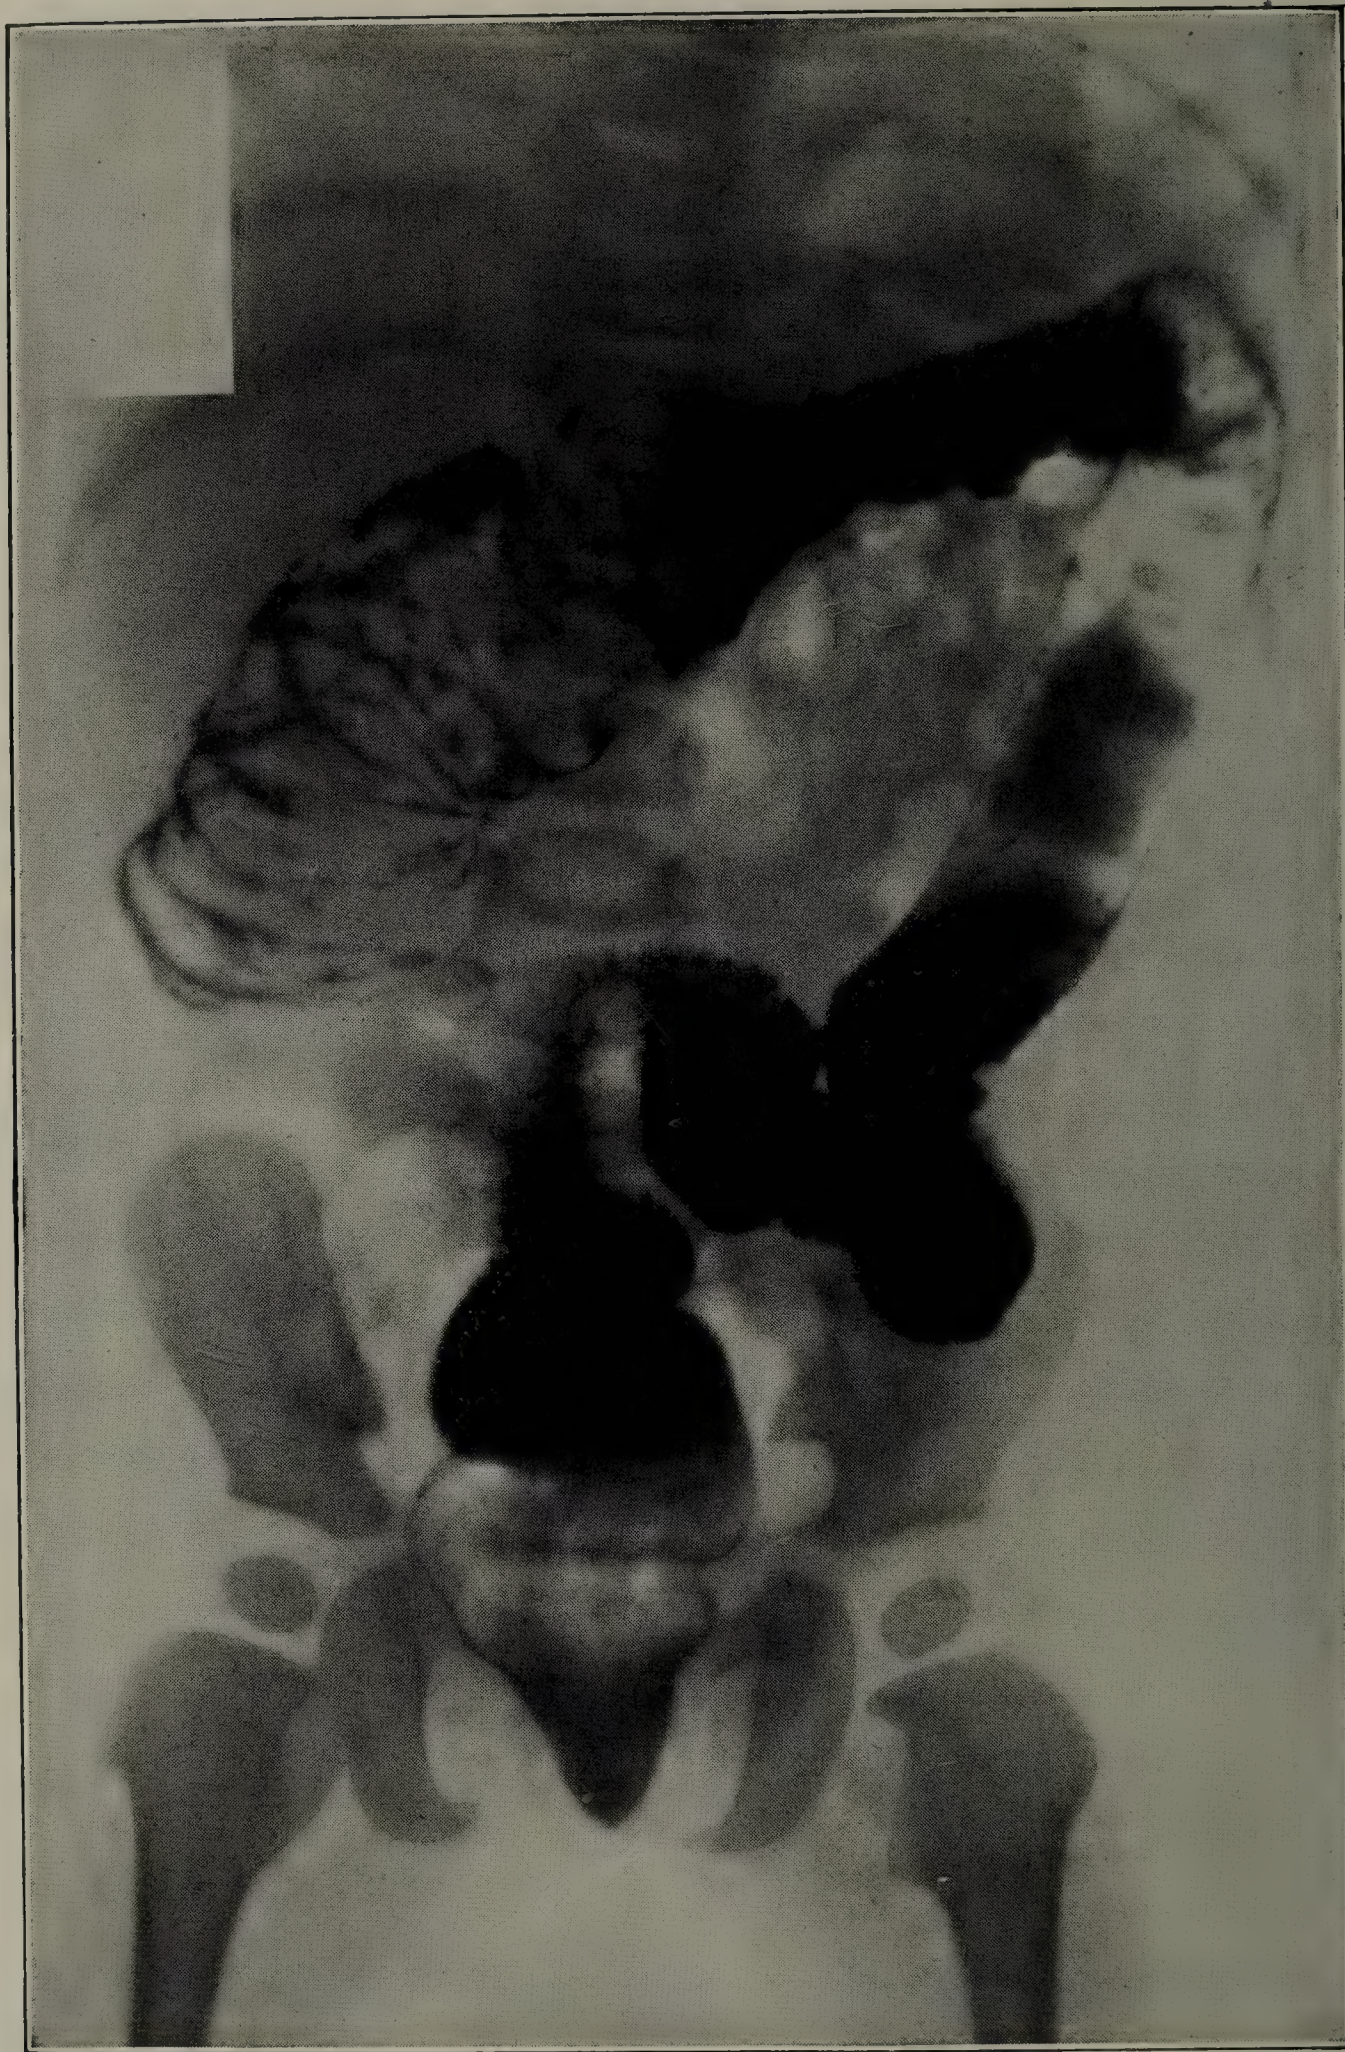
ROENTGENOGRAM AFTER OPAQUE ENEMA IN A CASE OF CHRONIC ILEOCECAL INTUSSUSCEPTION IN AN INFANT ELEVEN MONTHS OLD.
